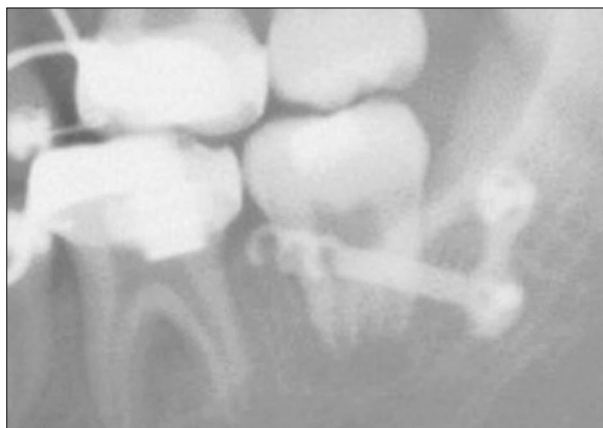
Radiograph of a miniplate TAD.
